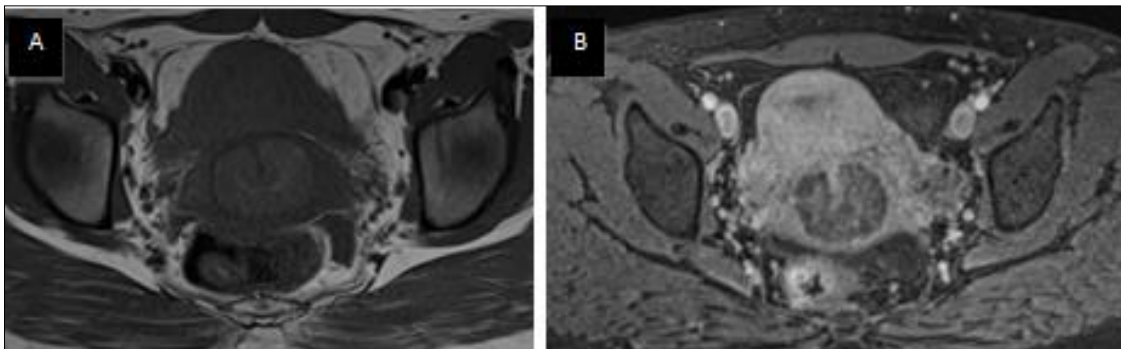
Axial T1 weighted MRI of the pelvis without (A) and with contrast. Nabothian cysts presented a low signal on T1, and there is no wall enhancement with intravenous gadolinium (B)
